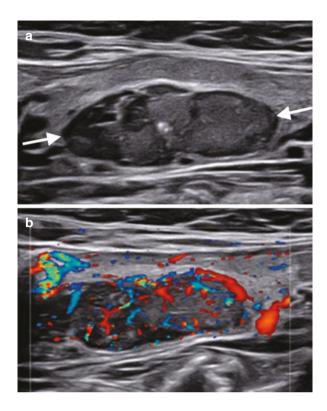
Plummer's adenoma. A hypoechoic nodule (a) with increased vascularity on Doppler imaging (b) is shown (arrows)
